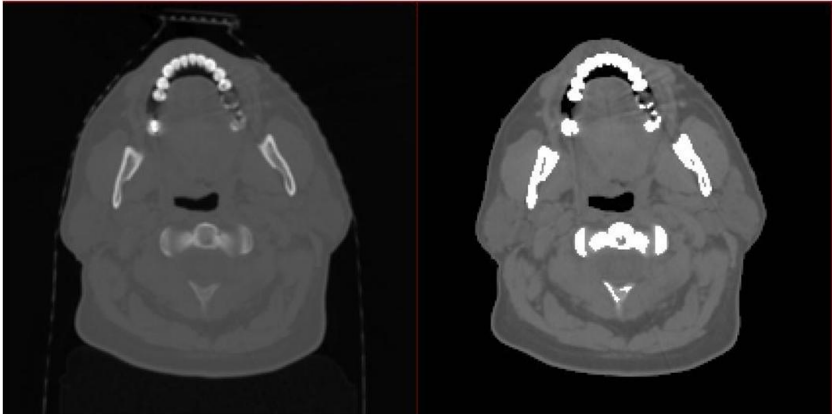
Pre-processing step of bone and background saturation. On the left: original CT image; on the right: saturated CT image.
